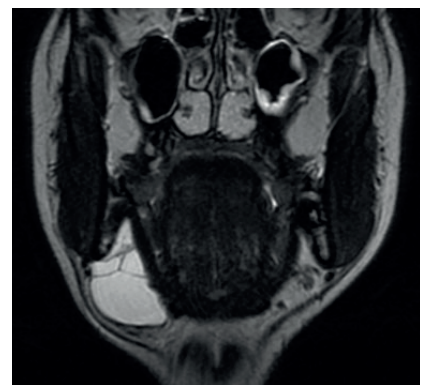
MRI plunging ranula, coronal view
